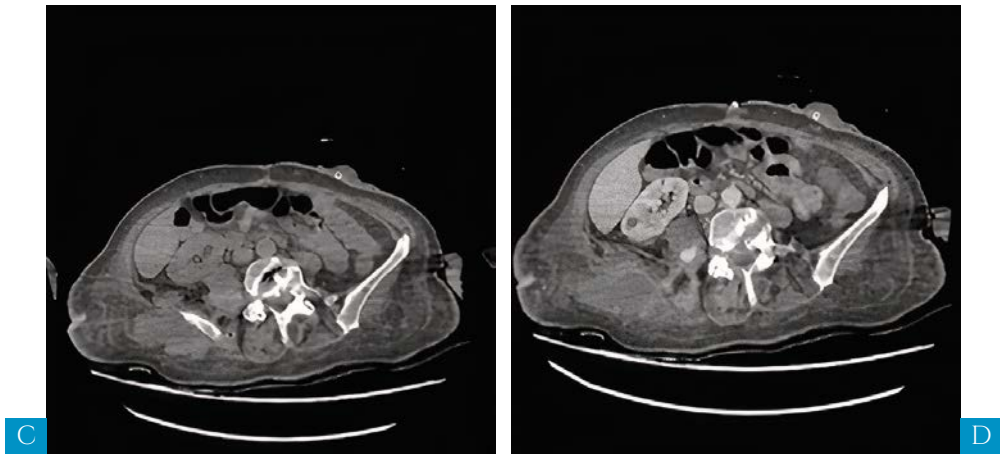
a, b, c, d: Abdominal CT
